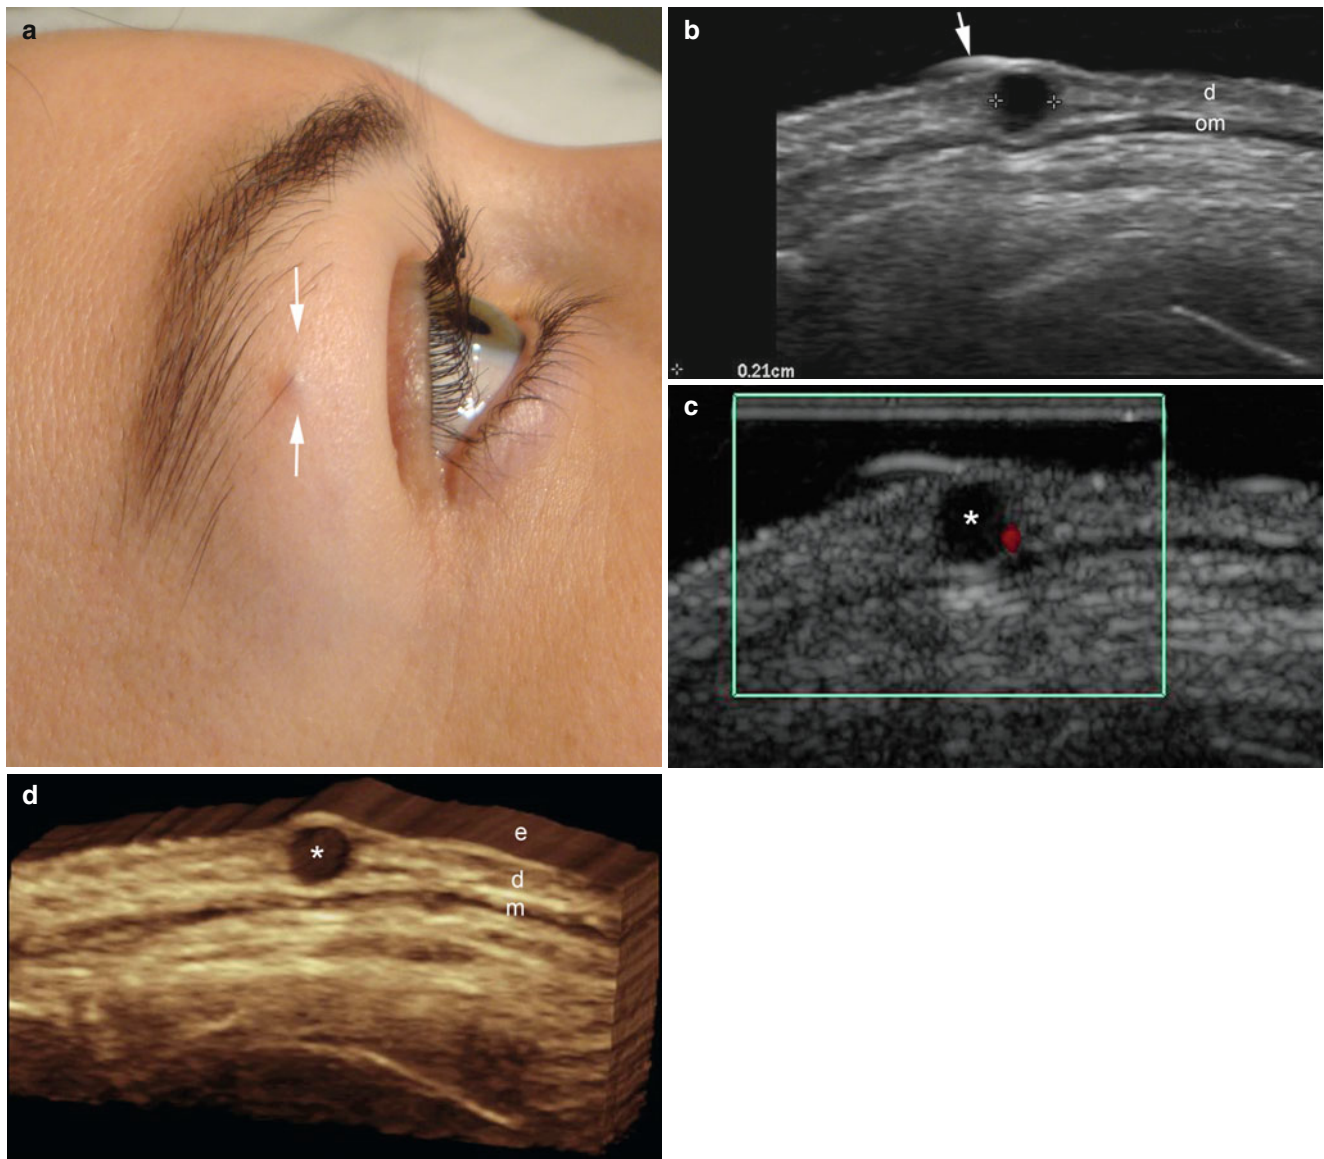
(a–d) Small dermoid cyst. (a) Clinical image shows a tiny nodule in the right ciliar region. (b) Ultrasound image (transverse view) demonstrates a 2.1 mm well defined *round-shaped* anechoic cyst (between markers). Notice the hyperechoic line (*arrow*) on top of the cyst that corresponds to the hair tract also visible in the clinical image.
